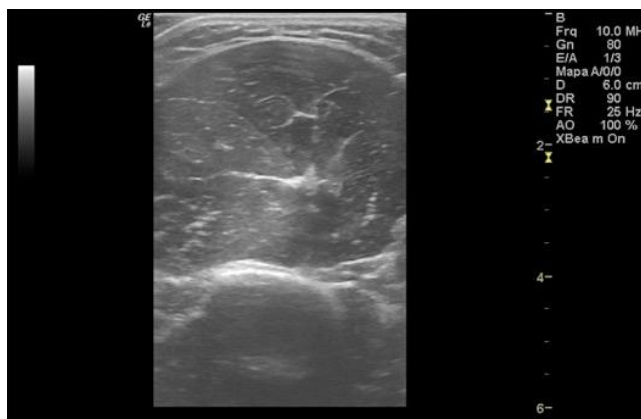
Typical ultrasound image of elbow flexor muscles at the biceps point.
